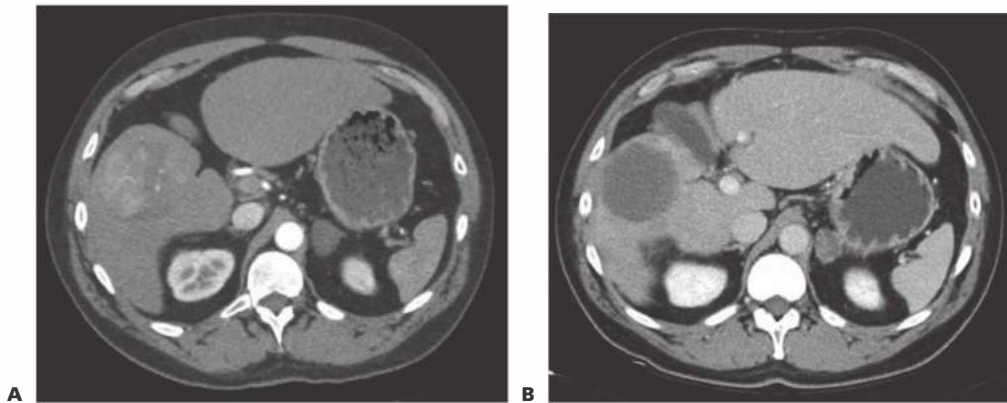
• A. Initial CT scan demonstrates a large, contrast-enhancing HCC in the right lobe of the liver prior to treatment. B. A follow-up CT 5 weeks after treatment using doxorubicin-loaded LC beads shows that the tumor is slightly smaller and there is no further contrast enhancement. Repeat imaging would then be performed about 3 months later.
